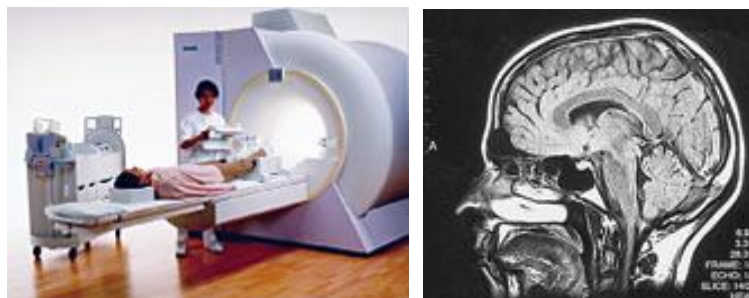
Magnetic resonance imaging device and the image obtained in it
